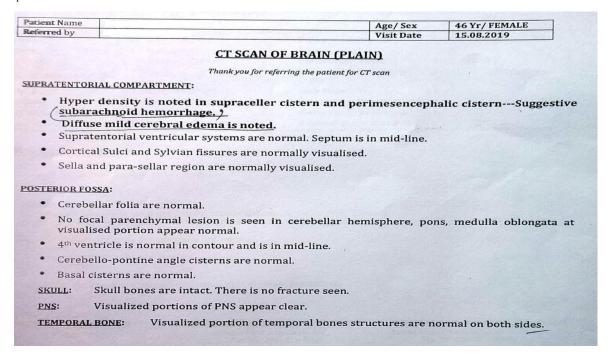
CT scan of the brain on august 15, 2019 shows subarachnoid haemorrhage with diffuse mild cerebral edema.
